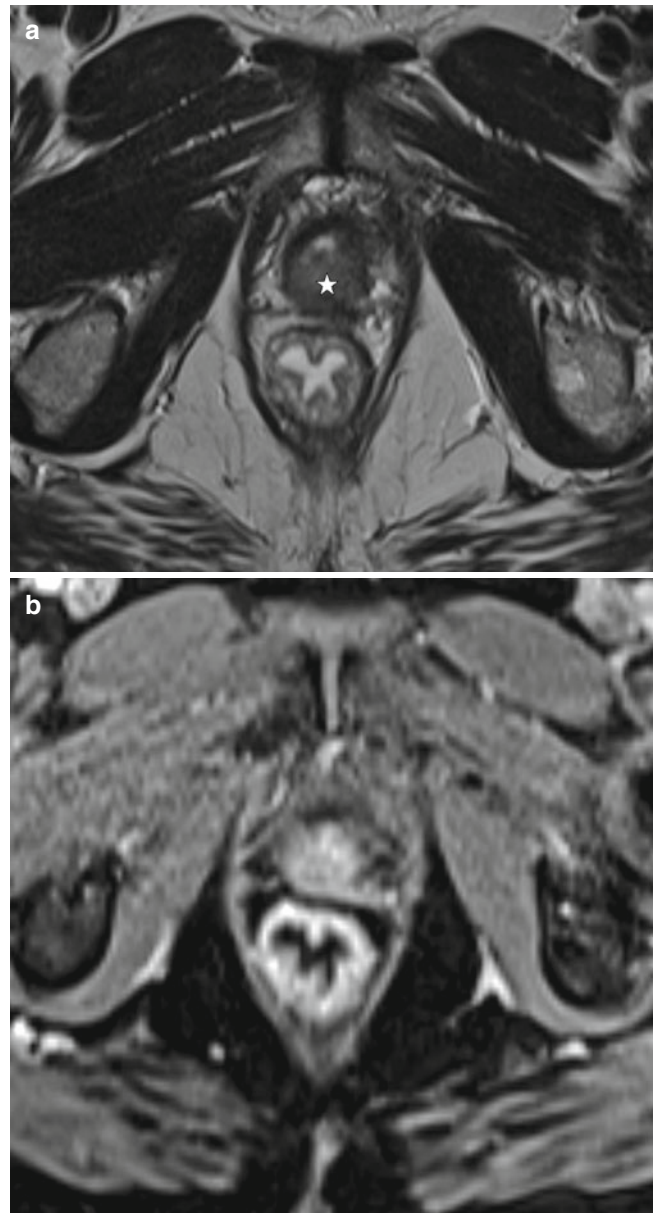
A 69-year-old patient with prostate cancer recurrence after radical prostatectomy. On a transverse T2W image (a), a nodular lesion (white star) is demonstrated in the posterior prostatectomy fossa, with higher signal intensity than the vesicourethral anastomosis. On dynamic contrast-enhanced MRI (b, at the same level as a), the recurrence enhances earlier and faster than postoperative fibrosis. DCE-MRI is valuable in the differentiation of prostate cancer recurrence from benign postoperative changes
